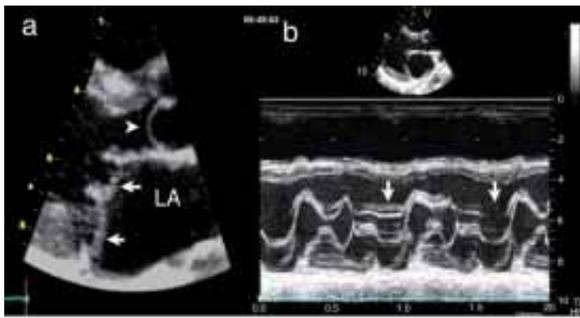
(a) Two-dimensional parasternal long axis image shows prolapse of both mitral leaflets (arrows) and prolapse of the noncoronary aortic leaflet (head arrow). (b) M-mode echogram at the level of the mitral leaflet during systole shows the image of a hammock (arrows). LA= Left atrium.
